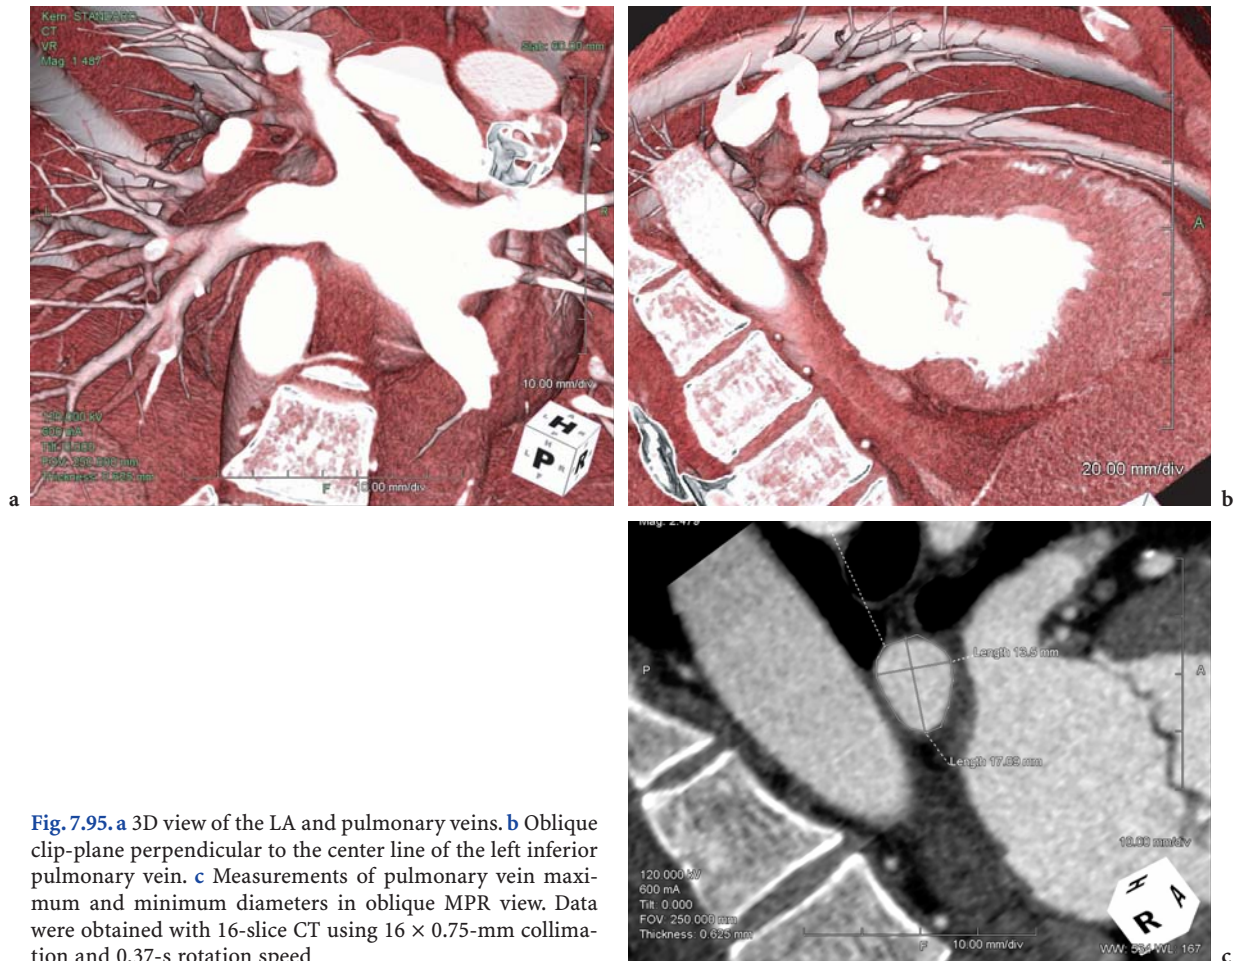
a 3D view of the LA and pulmonary veins. b Oblique clip-plane perpendicular to the center line of the left inferior pulmonary vein. c Measurements of pulmonary vein maximum and minimum diameters in oblique MPR view. Data were obtained with 16-slice CT using 16×0.75 -mm collimation and 0.37-s rotation speed
